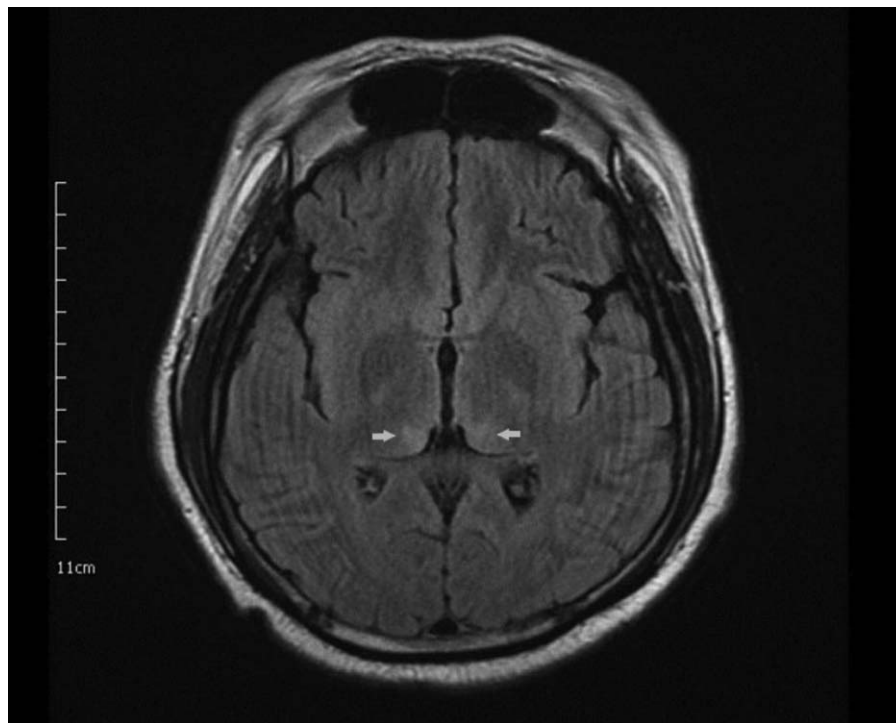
Brain MR imaging shows hyperintense lesions in the bilateral medial thalami (arrow), in fluid-attenuated inversion recovery (FLAIR) images. MR = magnetic resonance.
